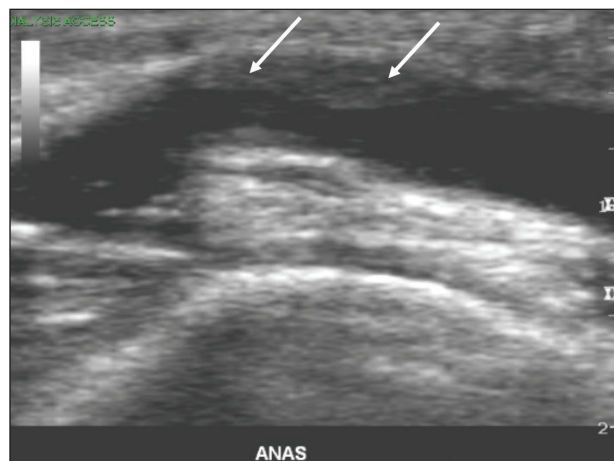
B-mode ultrasound image of a radiocephalic fistula demonstrating a juxta-anastomotic stenosis with venous neointimal hyperplasia (white arrows).
